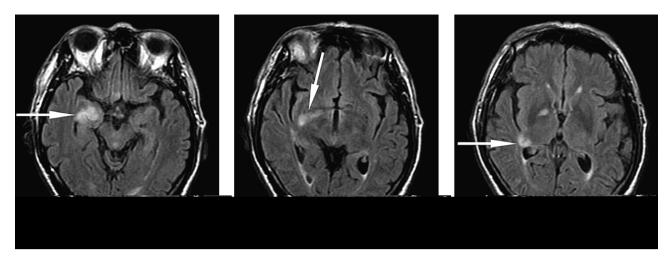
Axial T2-weighted fluid attenuated inversion recovery images of the brain at the level of the midbrain (a), hypothalamus (b), and thalamus (c). Hyperintense signal change is indicated by white arrows: in (a), the right mesial temporal lobe; in (b), the posterior limb of the right internal capsule; in (c), the right lateral geniculate body.
